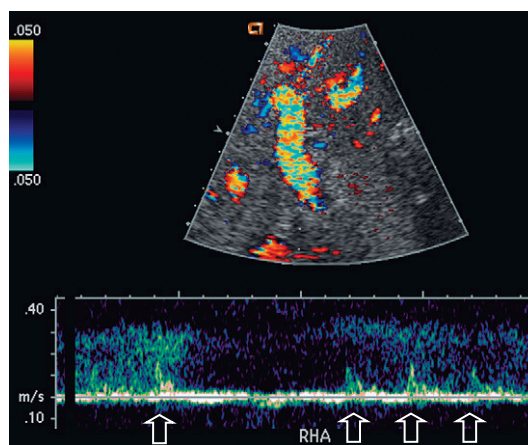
Spectral Doppler tracing of the porta hepatis on the first postoperative day. The hepatic artery was extremely difficult to identify (arrows) because of the thready, high resistance flow due to severe vasospasm. This patient may be considered a candidate for ultrasound contrast or a provocative test with vasodilating agents to confidently confirm arterial patency.
